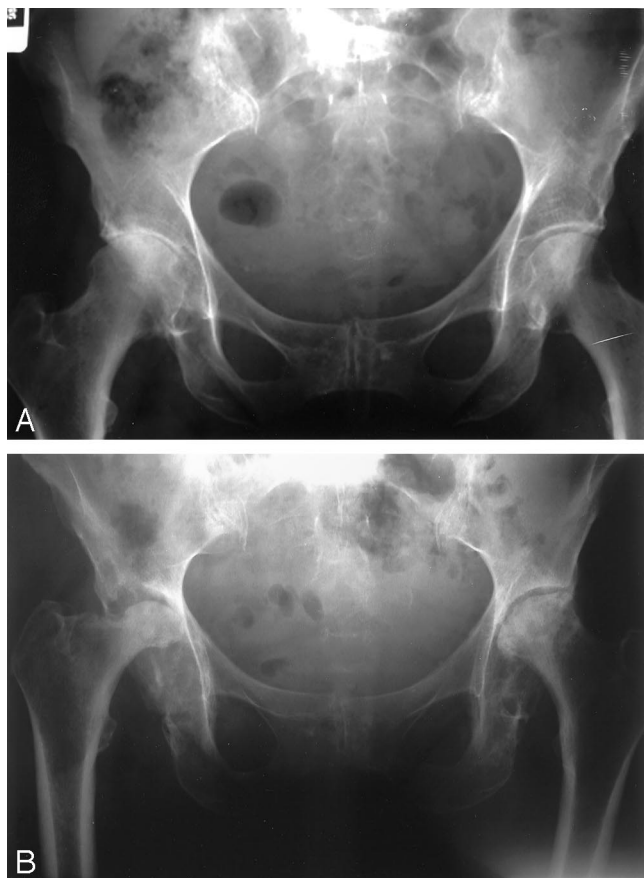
A, Plain radiographs of the hips showed osteoarthritis of the right hip and an essentially normal left hip. B, Radiographs show collapse of both femoral heads 8 weeks after spinal surgery. Note the degree of shortening, hence the patient's difficulty in maintaining mobility.
